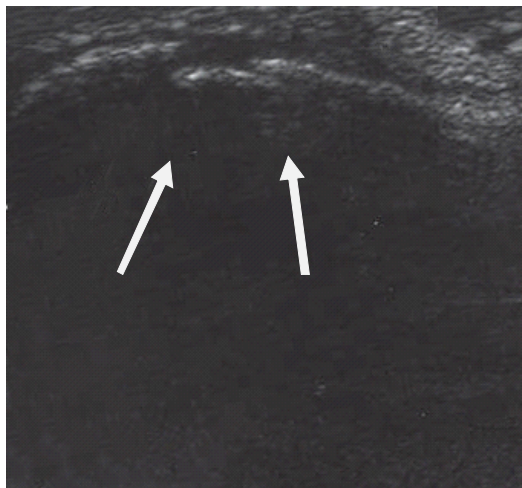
A 28-year-old woman with a normal Waters view and a fractured left lateral nasal wall in ultrasonography
